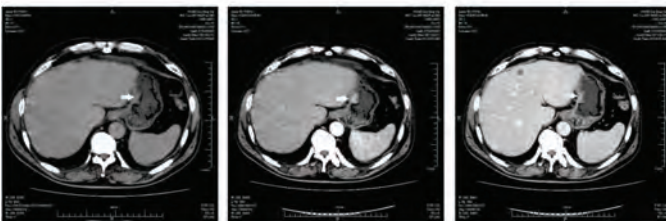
Abdominal contrast-enhanced computed tomography scan showed a lesion at the lesser curvature near to the cardia (arrow). The lesion was 1.6×1.1 cm in size and was apparently enhanced.
